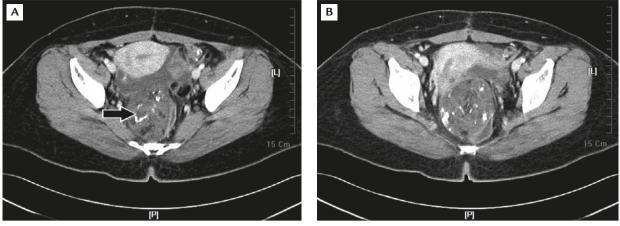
Contrast-enhanced axial pelvic computed tomography scans of the lower pelvis, (A) 336 mm below benchmark and (B) 351 mm below benchmark, obtained after completion of six cycles of the cisplatin, etoposide and bleomycin chemotherapy, disclosed an enlarged, smoothly marginated mass with streaked multiple calcifications (A, arrow).
